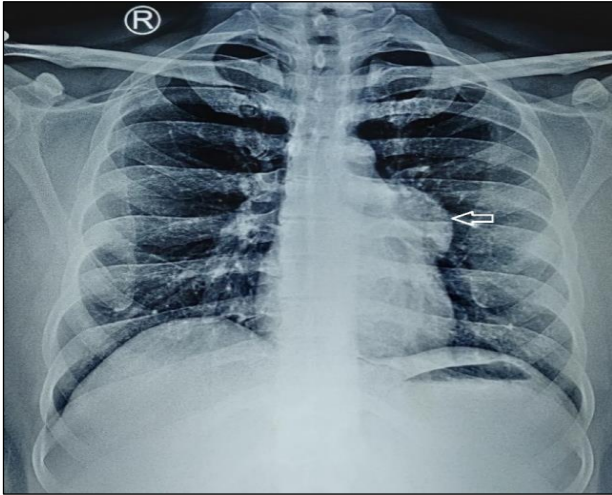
The chest radiograph showed a left sided parahilar opacity (arrow).
